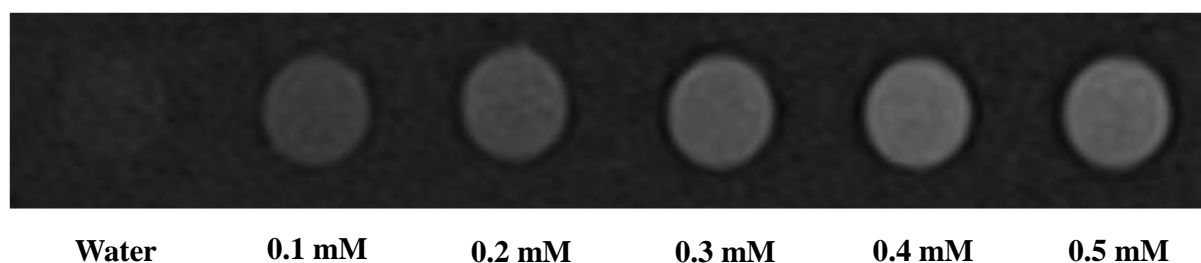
T₁-weighted *in vitro* MR images of aqueous dispersions of PEG functionalized manganese oxide@CF nanosystem with different Mn concentrations
